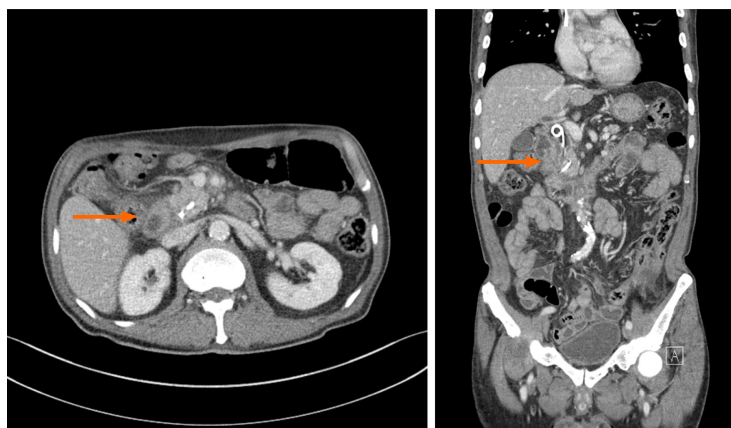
Computed tomography of the abdomen two weeks after pancreatic stent placement. Disappearance of adjacent fluid collection and edematous change of head of pancreas, and healing of the duct leakage site finding were seen.
